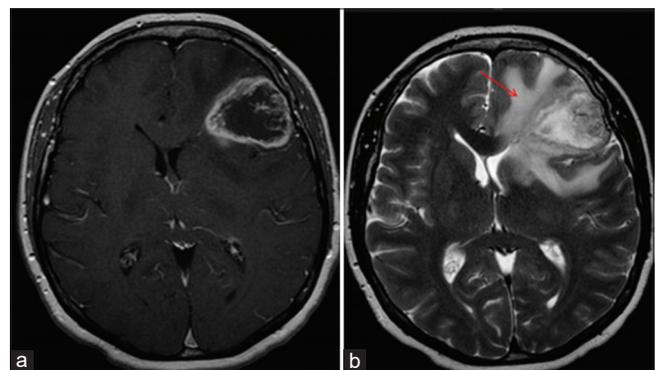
Contrast-enhanced magnetic resonance imaging shows a tumor with perilesional edema (a) well-circumscribed lesion with enhancement representing edema regular in shape, size <2 cm. (b) tumor with necrosis and edema irregular in shape with >2 cm in size (indicated by arrow).
